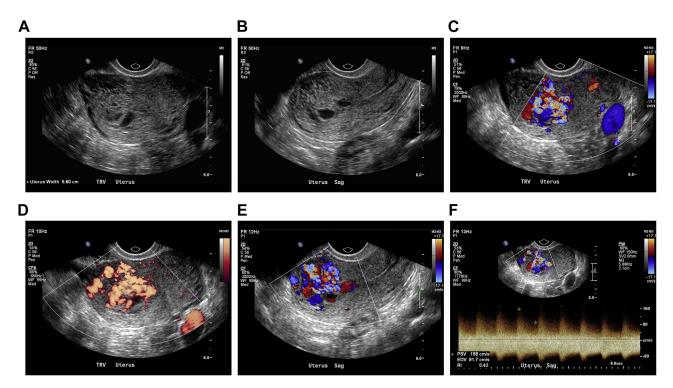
Transverse (A) and longitudinal (B) gray scale sonographic images of the uterus demonstrate a focal collection of tubular, anechoic to hypoechoic echoes in the right uterine. No discrete soft tissue mass or mass effect was appreciated. Corresponding transverse color Doppler (C) and power Doppler (D) images as well as a longitudinal color Doppler (E) image demonstrate evidence of increased blood flow within the tubular spaces and adjacent myometrium. Spectral Doppler (F) image exhibits areas of high velocity, low-resistance flow within the area of concern.
